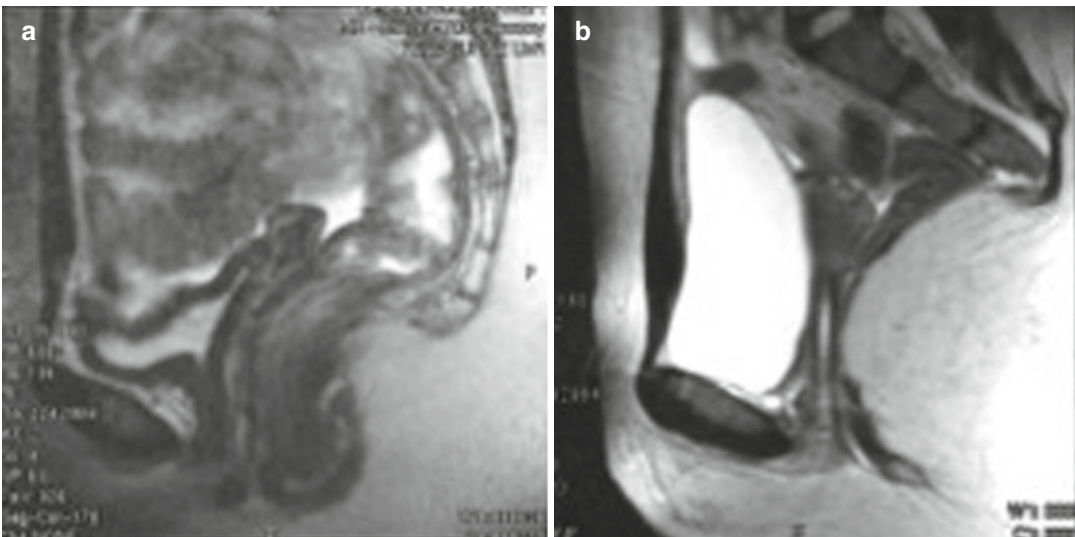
(a) MRI image of the congenitally closed vesico-rectal space. (b) MRI image of the newly formed vagina using Adamyan's technique.
